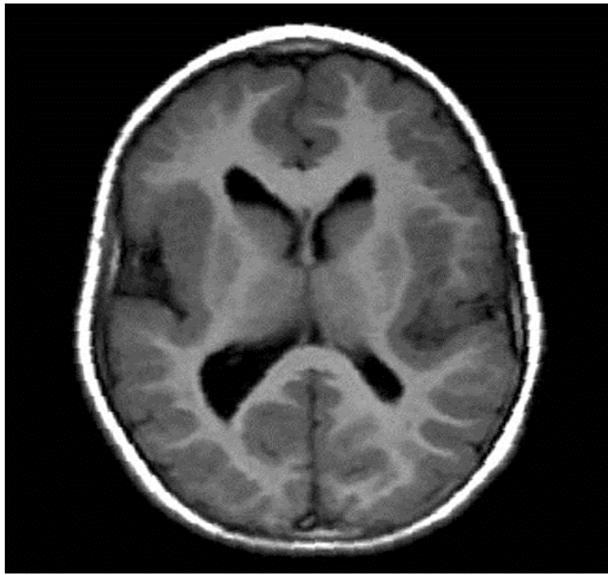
B – MRI; dilated cisterna magna (or cerebellomedullary cistern); hypoplasia of the corpus callosum; dilated fourth ventricle; gray matter heterotopia; post-surgical anatomy of occipital myelomeningocele closure.
